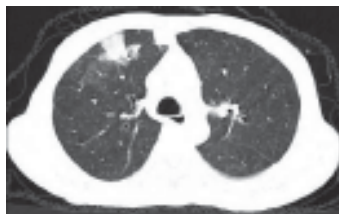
HRCT reveals a halo of ground glass haze surrounding the wedge shaped opacity (infarct)
